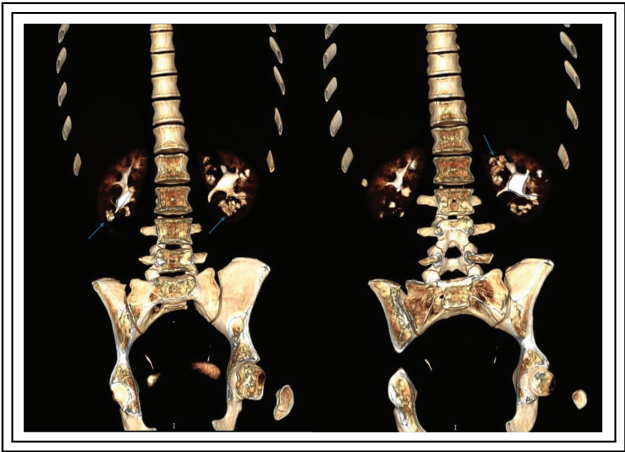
CT reconstruction showing dilated medullary collecting ducts (blue arrows)
